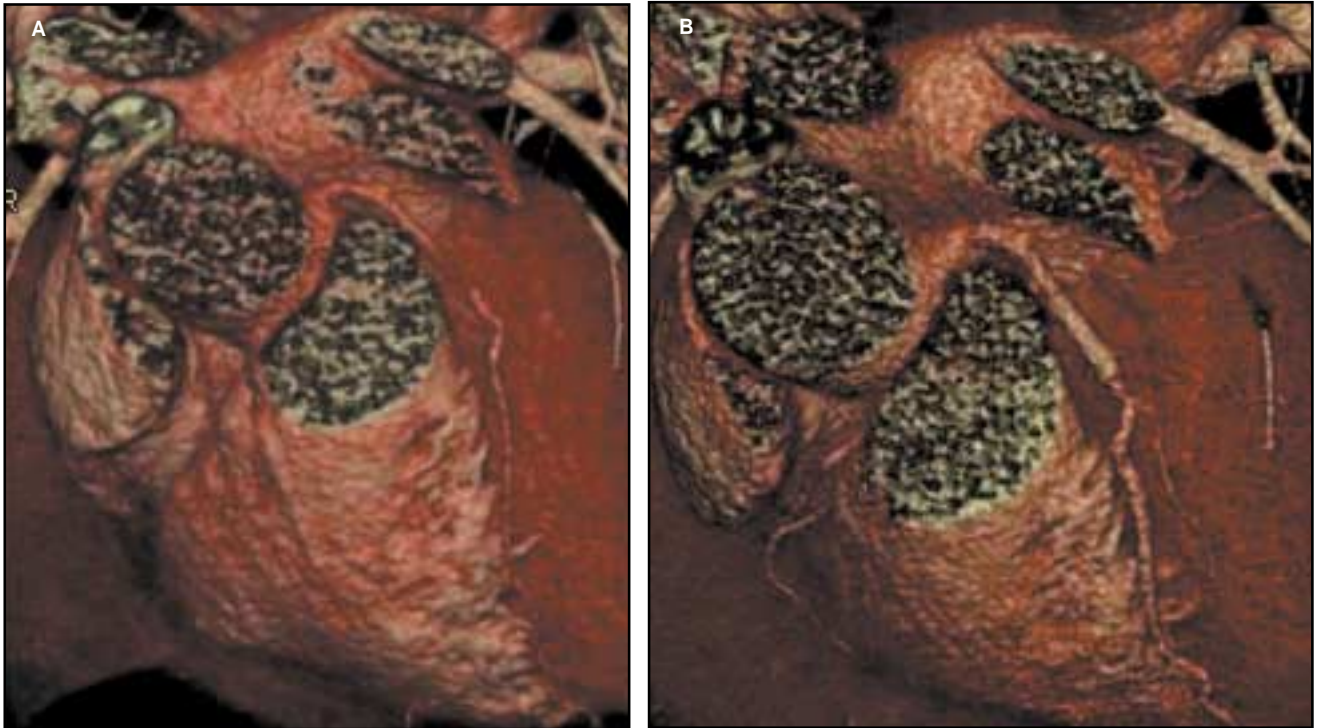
Three-dimensional renderings from the same patient imaged (A) with a 4-row CT scanner and (B) with a 16-row CT scanner 1 year later. (A) The 4-row CT scanner detected a stenosis in the proximal portion of the left anterior descending coronary artery. (B) The image acquired on the 16-row scanner shows more image noise but better visualizes small arteries, such as the diagonal branches and the right coronary artery.
